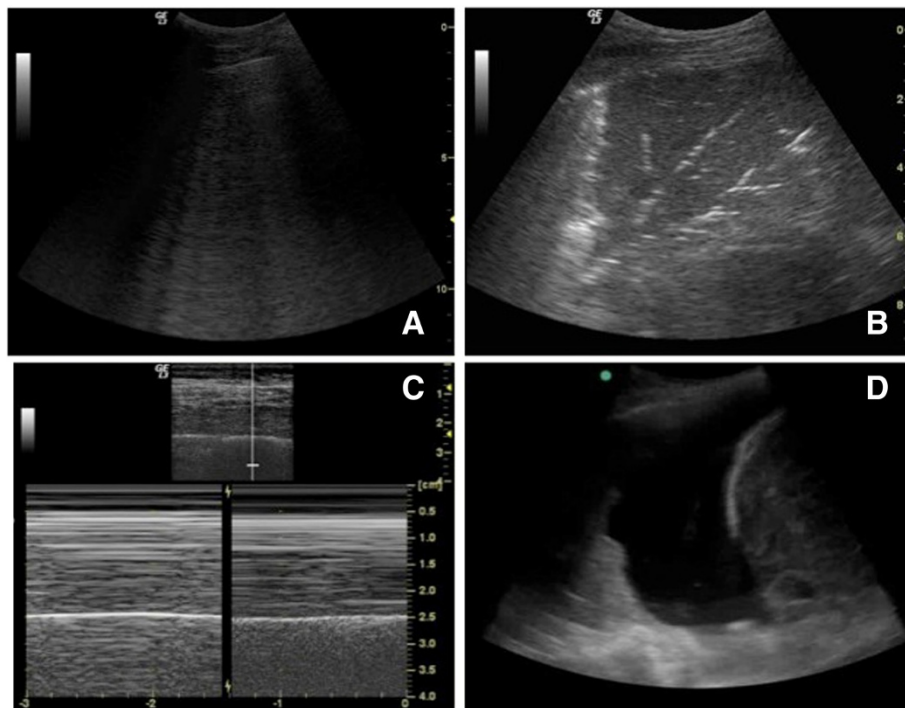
Lung ultrasound major syndromes. (A) Diffuse B-lines representing interstitial syndrome. (B) Alveolar consolidation. (C) M-mode findings of a pneumothorax (stratosphere sign or bar code sign; left), and a normal lung (seashore sign). (D) Pleural effusion.
